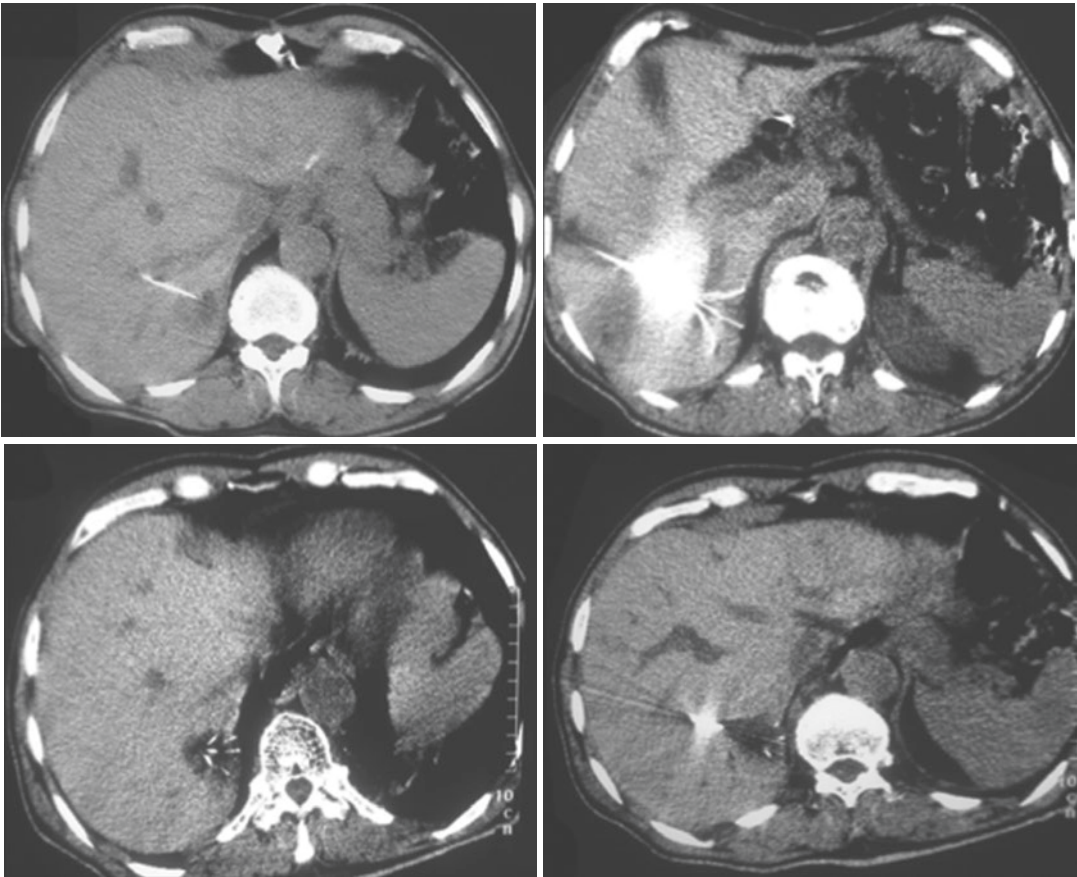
CT-guided RFA of metastatic lesion in the right lobe of the liver
